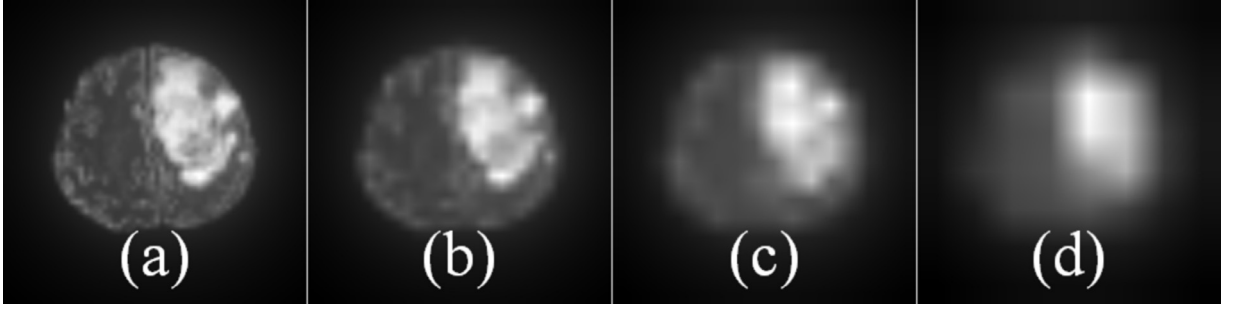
Saliency map of pseudo-colored MR image of the whole tumor region of Fig. 2 (a) at different scales. Patch sizes of (a) 4×4 , (b) 8×8 , (c) 16×16 , and (d) 32×32 .
